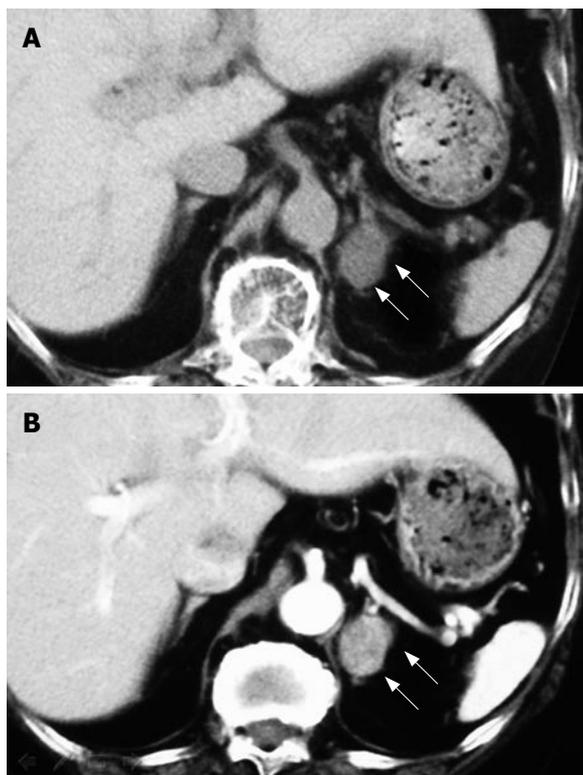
Abdominal CT. Plain (A) and enhanced (B) CT revealed a left adrenal mass (white arrows) measuring 3.5 cm × 3.0 cm in diameter.
